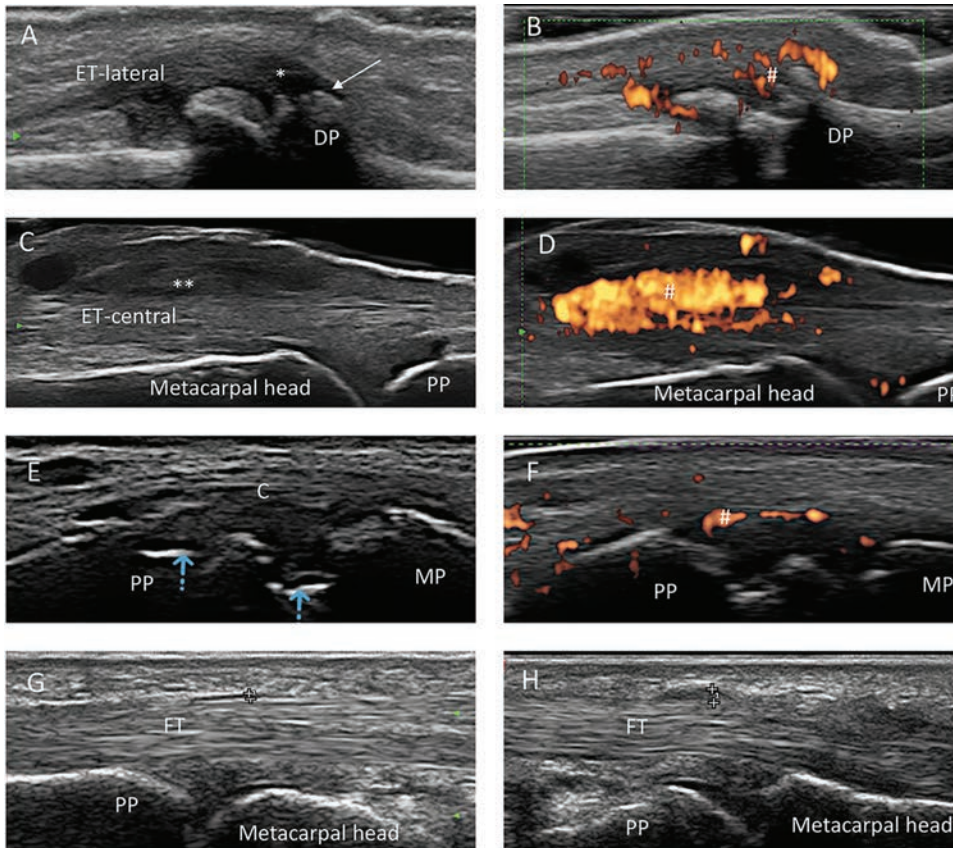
Examples of the extrasynovial lesions seen on ultrasound. Longitudinal ultrasound scans of the digit from (A–D) dorsal, (E–F) lateral, and (G–H) volar surface. (A–B) Hypoechoogenicity and thickening (*) at the extensor tendon lateral bands' insertion to the distal phalanx (DP), enthesophyte (arrow), and enthesal Doppler signals (#). (C–D) Hypoechoogenicity and thickening () of the extensor tendon paratenon, proximal to the metacarpal head with Doppler signals (#). (E–F) Erosions at the collateral ligament origins (blue arrows) and Doppler signals (#). (G–H) Normal thickness of the A1 pulley (calipers in panel G) and increased thickness in a patient with PsA (calipers in panel H). Reproduced with permission: C–F: CRUS (Canadian Rheumatology Ultrasound Society) Ultrasonography Guide, Volume 3, (Educational Resources — Canadian Rheumatology Ultrasound Society [crusurc.ca]). G–H: Ilaria Tinazzi, Unità Semplice di Reumatologia, Ospedale Sacro Cuore-Don Calabria Negrar (VR; ilariatinazzi@yahoo.it). C: collateral ligament; DP: distal phalanx; ET-central: extensor tendon central slip; ET-lateral: extensor tendon lateral band; FT: flexor tendon; MP: middle phalanx; PP: proximal phalanx; PsA: psoriatic arthritis.
